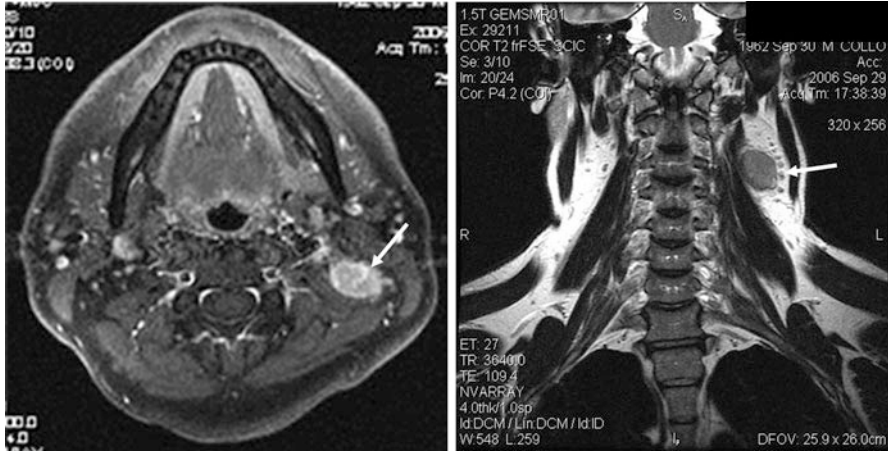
MRI scan. Metastatic lymph node in the left posterior cervical space. The pathologic lymph node, which is hyperintense in the T1 and T2 sequences (*arrows*), is located in an “US blind spot” and was not revealed by a previous US examination
